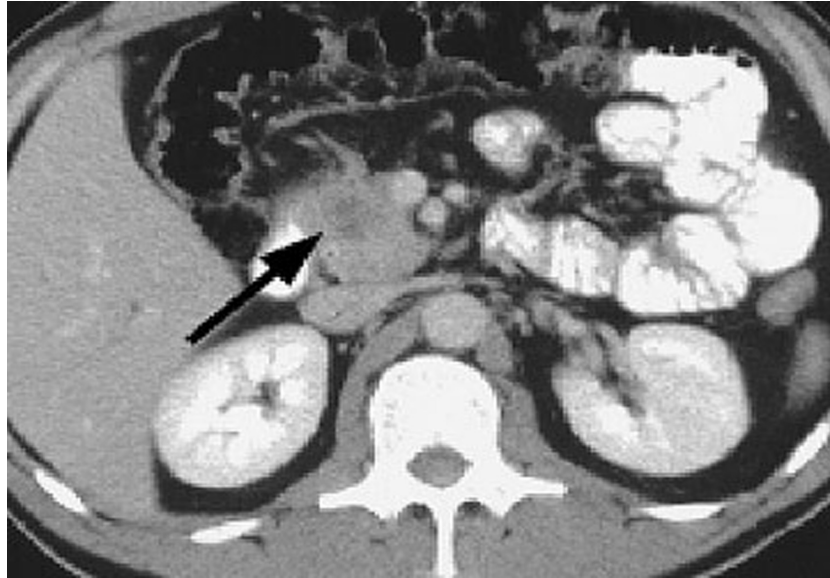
3 CT Scan-Pancreatic head carcinoma
